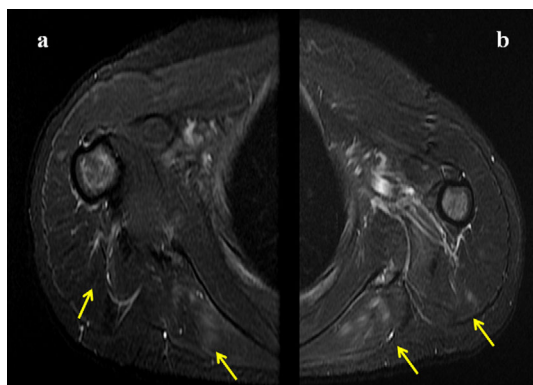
MRI findings on admission in the bilateral upper arms. Right upper arm (a) and left upper arm (b). T2-weighted STIR imaging showed hyperintensity in the muscle (arrows). MRI: magnetic resonance imaging, STIR: short-tau inversion recovery
